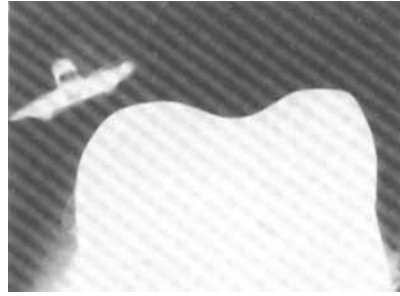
Skyline radiograph of a knee in flexion demonstrating patella subluxation onto the lateral condyle of the femoral component.
